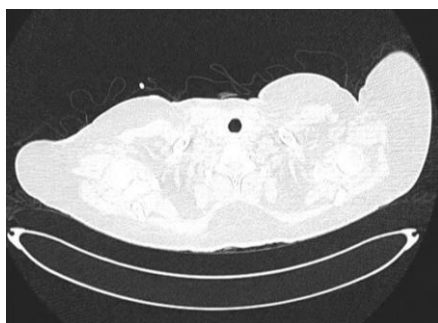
CT Chest: CORADS 6
